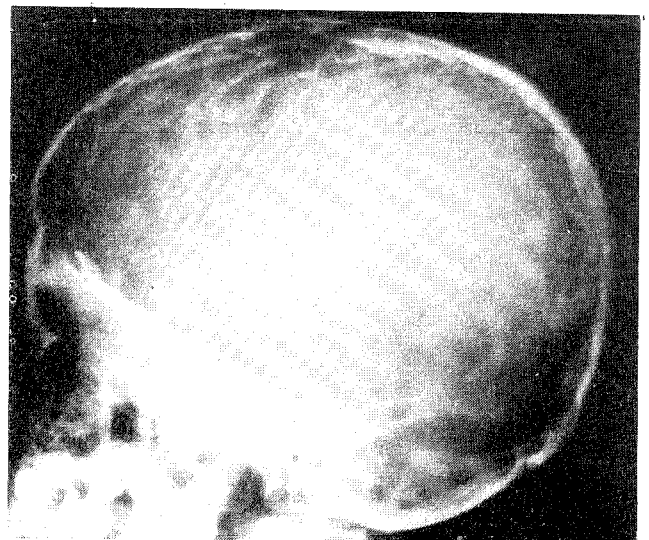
X-ray skull of the patient.
